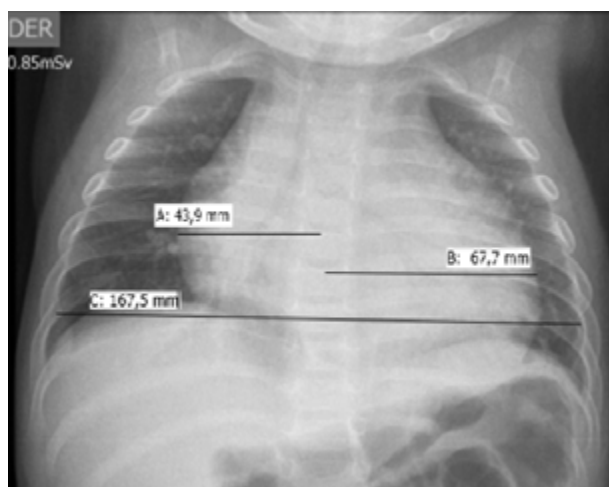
Initial chest x-ray.
